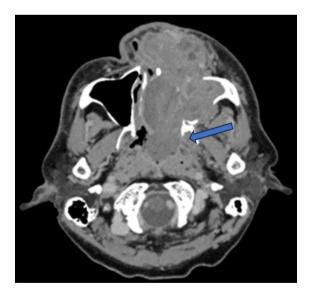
CT axial view shows irregular enhancing mass at the nasal cavity/left maxillary sinus.
